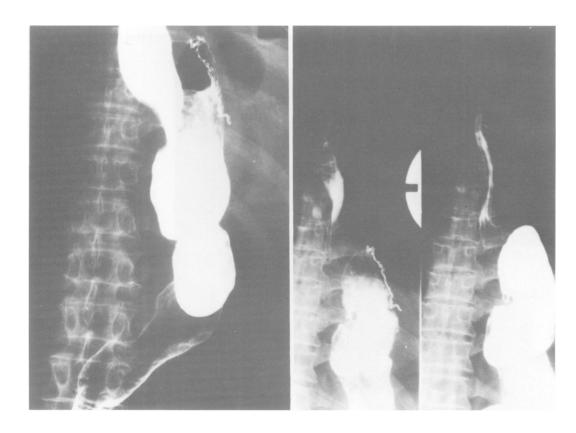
Radiographs of a satisfactory anastomosis. On the left, a good formation of the stomach bubble was noticeable. On the right, reflux did not occur in a head down position of 20 degrees.
